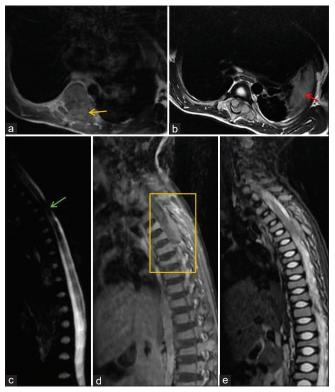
(a and b) MRI T1 contrast and T2 axial images showing soft tissue masses causing spinal cord compression and moderate to severe left neural foraminal narrowing (yellow arrow in a). Furthermore, note the heterogenously hyperintense extra pleural soft tissue mass along the left lateral chest wall on axial T2 MRI image (arrow in b). (c-e) MRI sagittal myelogram, T1 contrast, and T2 images showing spinal cord compression (green arrow in c).
